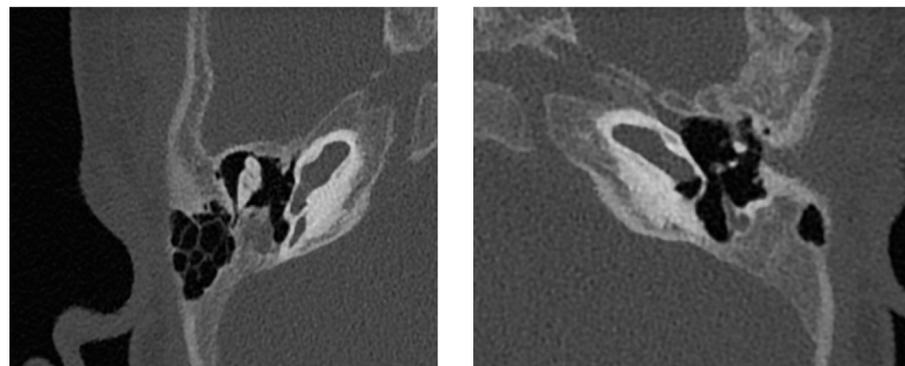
CT of the temporal bone, axial cuts, showing bilateral hypoplastic cochleas
